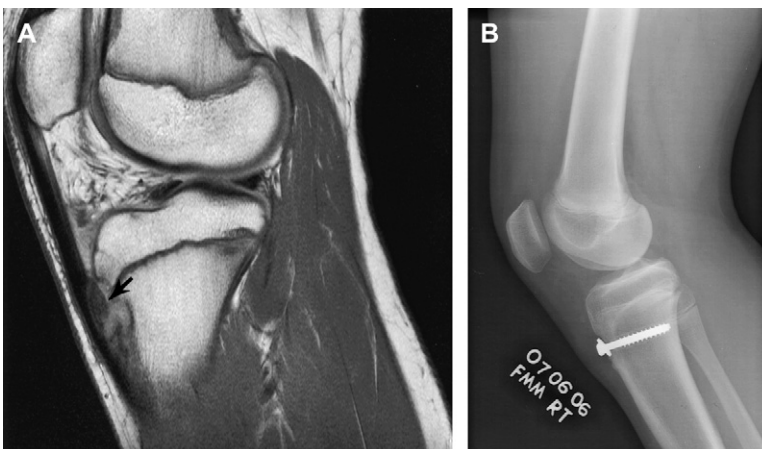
Type I tibial tuberosity avulsion. Sagittal T1-weighted image (A) demonstrates a tibial tuberosity avulsion (arrow). The fragment was reduced with a cancellous screw (B).
